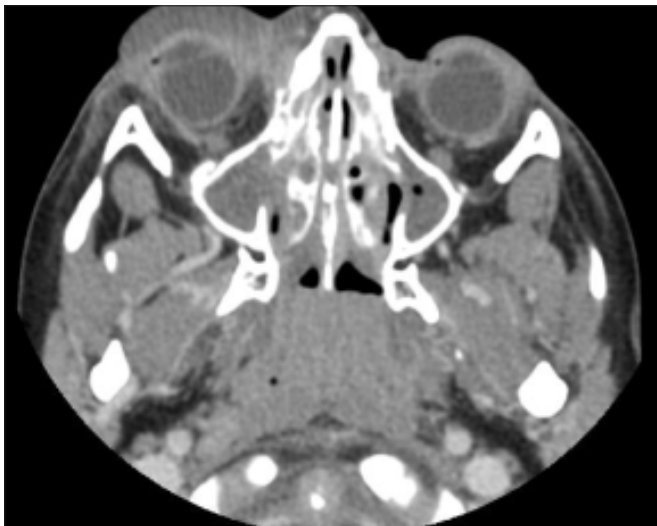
Axial CT of Orbits (post contrast) showing right pre-septal soft tissue swelling.
